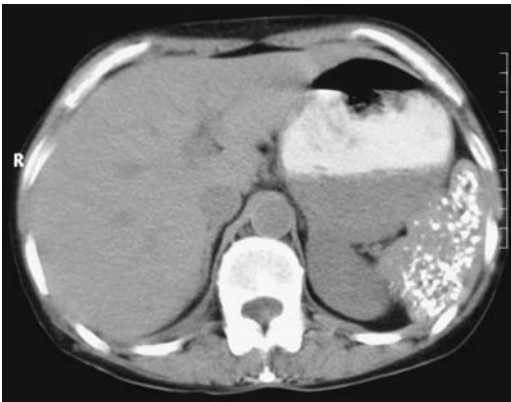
Extensive splenic calcifications detected by CT (arrow). Either tuberculosis or histoplasmosis can produce these changes. (Courtesy of Algidas Basevicius, M.D., Kaunas Medical University, Kaunas, Lithuania.)
